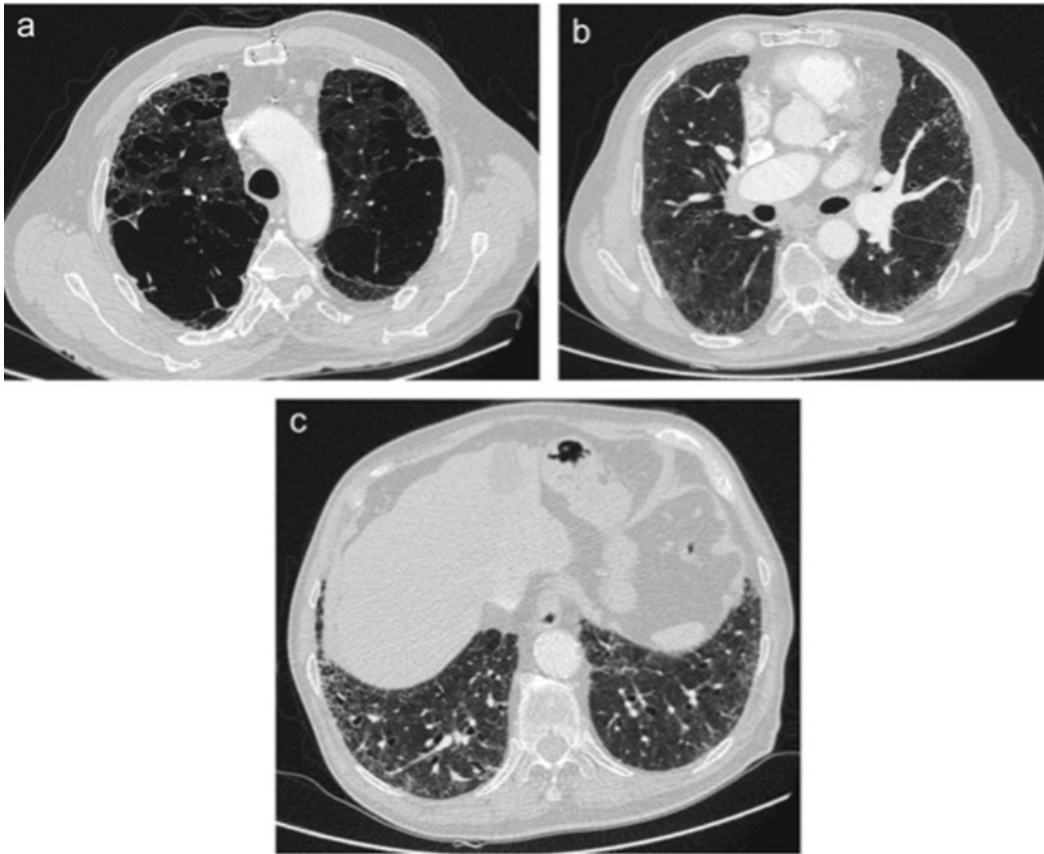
HRCT images of CPFE with emphysema in the upper lobes and fibrosis in the lower lobes.
